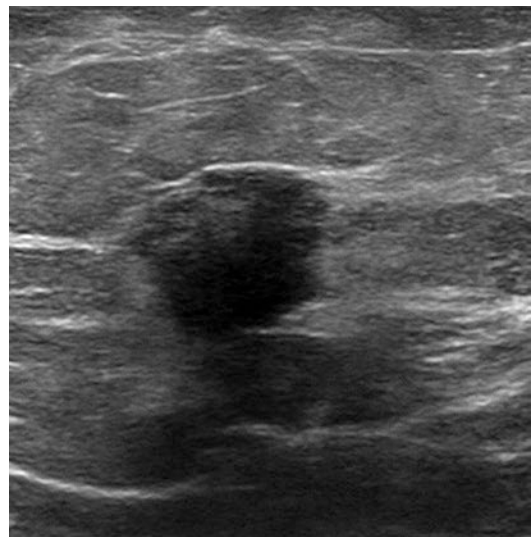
Spiculated breast mass on ultrasound highly suggestive of cancer
